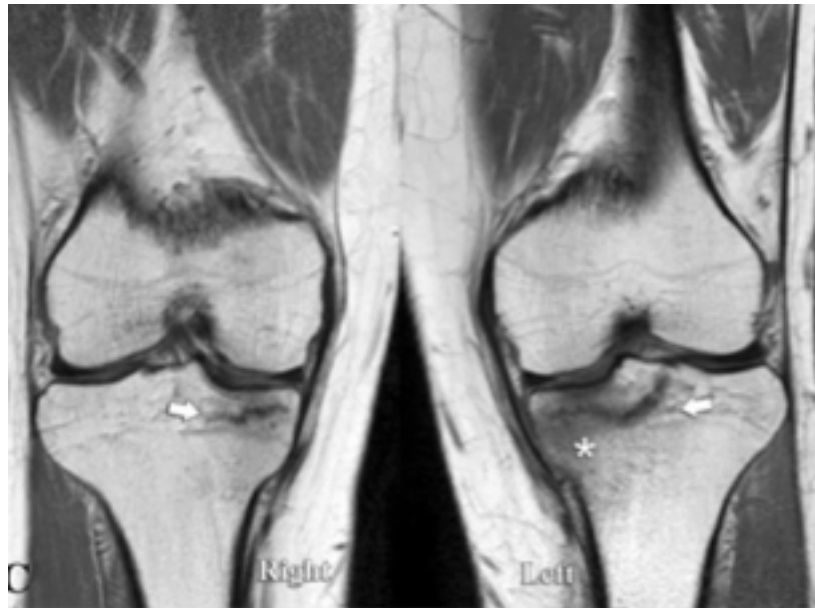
A T1-weighted MRI image of bilateral BSI to the tibial plateau.
